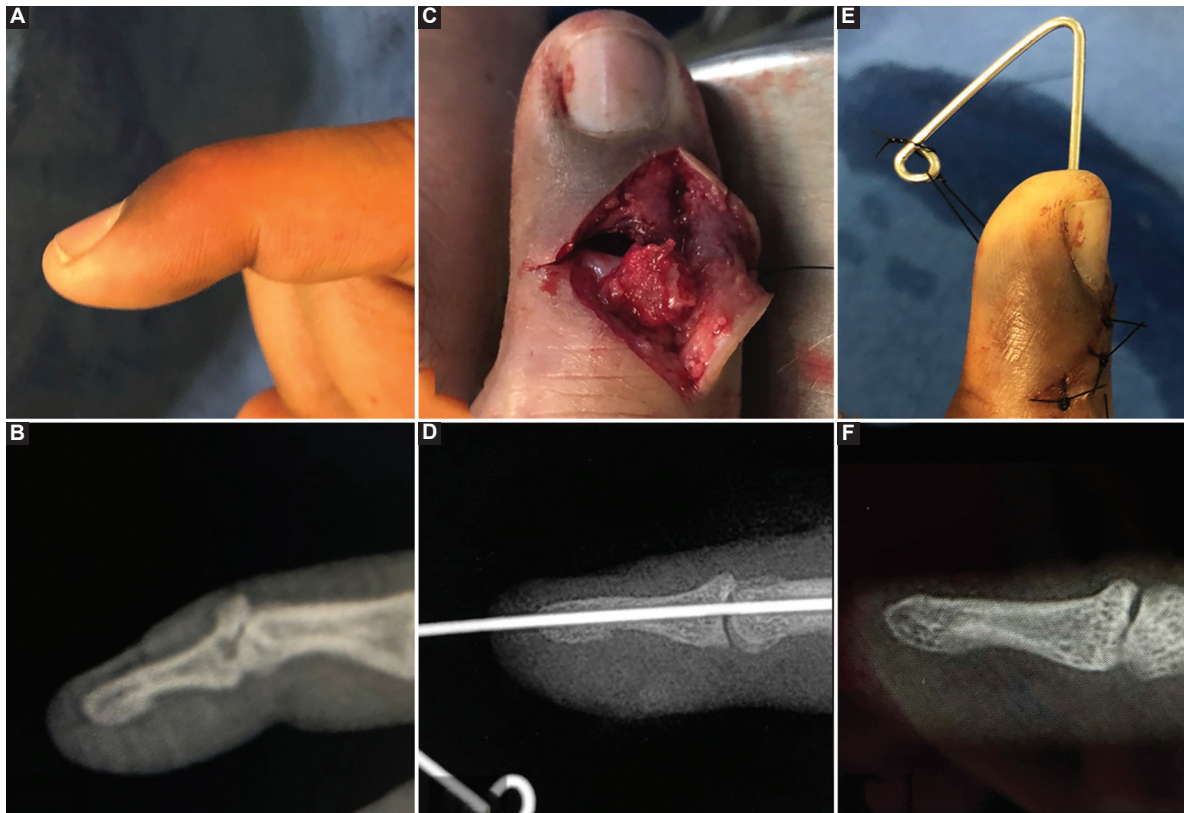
Example case of wire. A: preoperative image. B: lateral view. C: surgery. D: lateral view immediate radiograph. E: lateral view the immediate photograph. F: follow up without K-wire and nylon.
